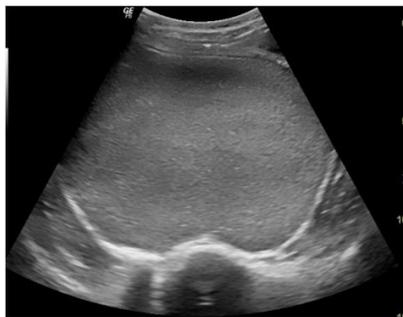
Transabdominal ultrasound image demonstrates the large intra-abdominal collection with internal hyperechoic contents.
